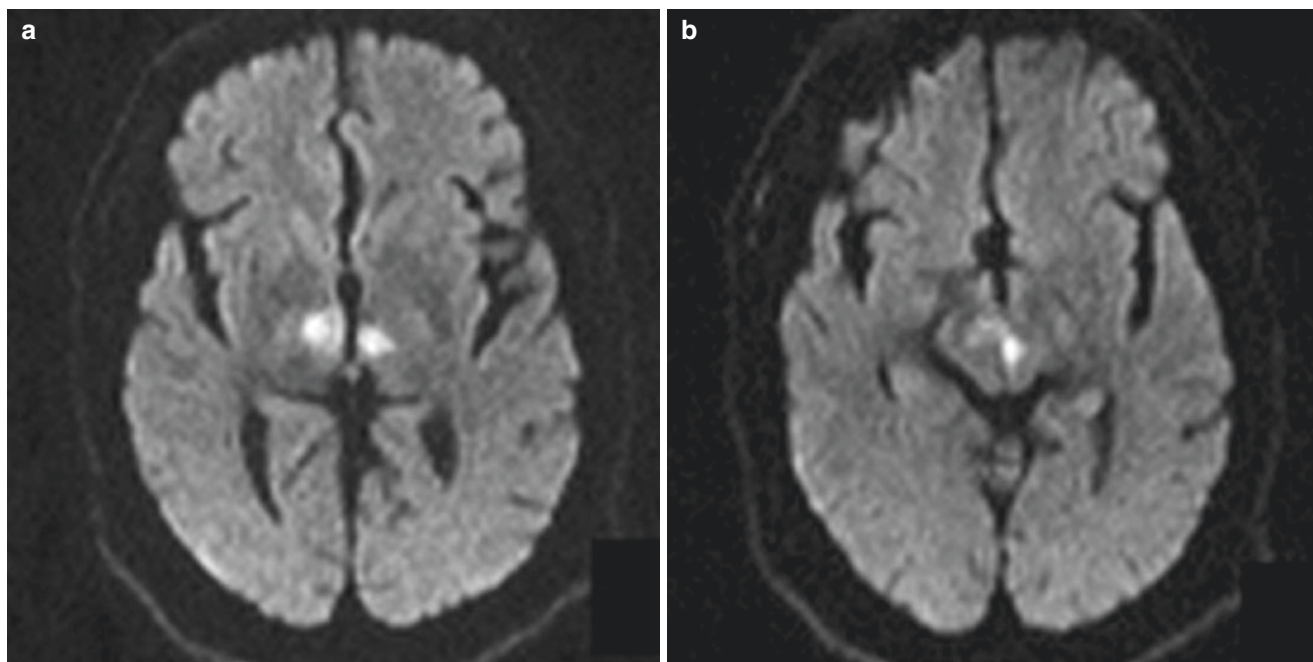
Artery of Percheron infarction. DWI images show acute infarction of bilateral median thalami (a) and rostral midbrain (b) in the territory of artery of Percheron
